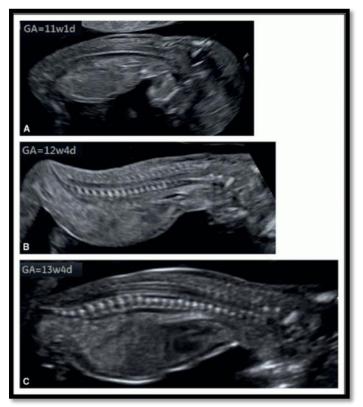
2 - D ultrasonography of the fetal spine in three fetuses at (A) 11, (B) 12, and (C) 13 weeks of gestation. (The Fetal Skeletal System | Radiology Key, n.d.)
